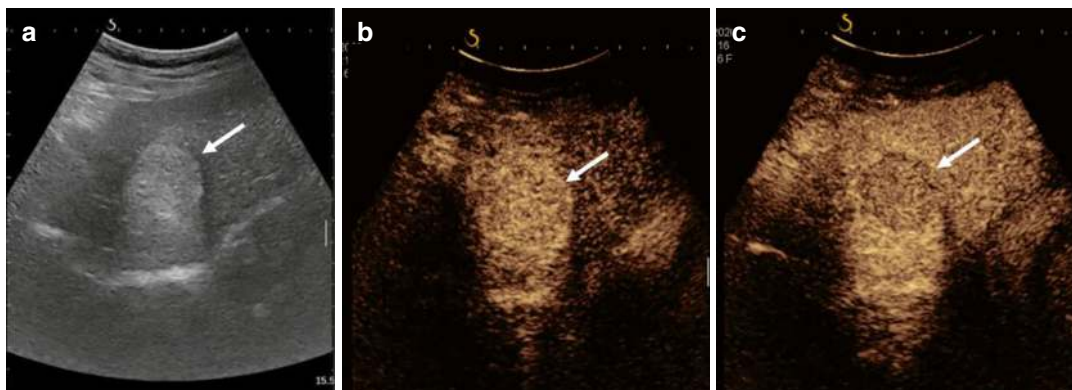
A 40-year-old male with hepatocellular carcinoma. (a–c) Ultrasonography image of the liver (a) showed a well-defined echogenic lesion in the liver (arrow). The background liver shows coarse echotexture.
